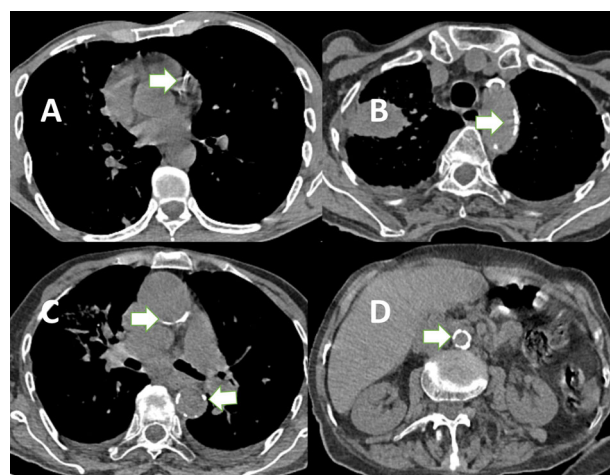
(A-D) — Axial Noncontrast Computed Tomography (NCCT) Images of Thorax (A-C) and Abdomen (D) show Coronary Artery Calcification (A), Aortic Arch Calcification (B), Ascending & Descending Thoracic Aorta Calcification (C), & Abdominal Aorta Calcification (D) in different patients (arrows).
